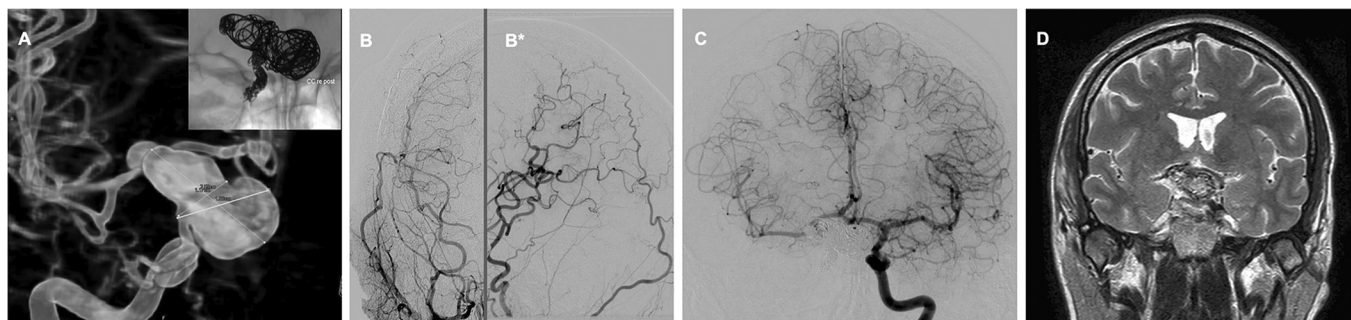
Three-dimensional-digital subtraction angiography image of a patient in their 40s complaining of headaches and right-sided progressive impairment of visual acuity caused by a right-sided supraclinoidal fusiform aneurysm (A). Insert shows coil-occluded internal carotid artery aneurysm. Vision recovered completely within 7 months. (B) robust bypass filling of the right middle cerebral artery territory (anteroposterior and lateral view). (C) cross flow from the left side. (D). follow-up MRI demonstrating the thrombosed aneurysm.
